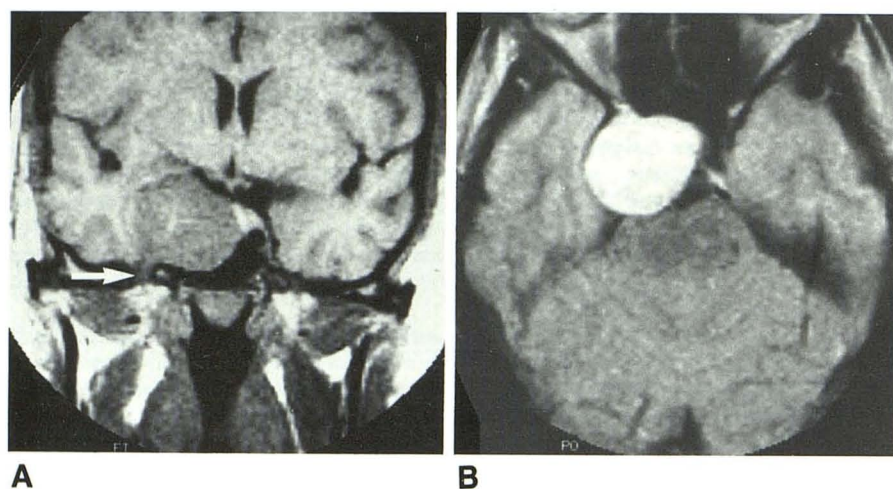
A and B, Case 1. Trigeminal schwannoma of right gasserian ganglion with smooth margins, relatively low signal intensity on T1-weighted image (A, 550/26), and high homogeneous signal intensity on T2-weighted image (B, 2000/80). Note involvement of mandibular division (arrow) in A.
